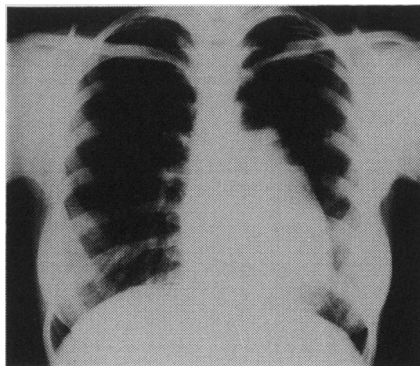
Chest X-ray consistent with leftward rotation of the heart.
